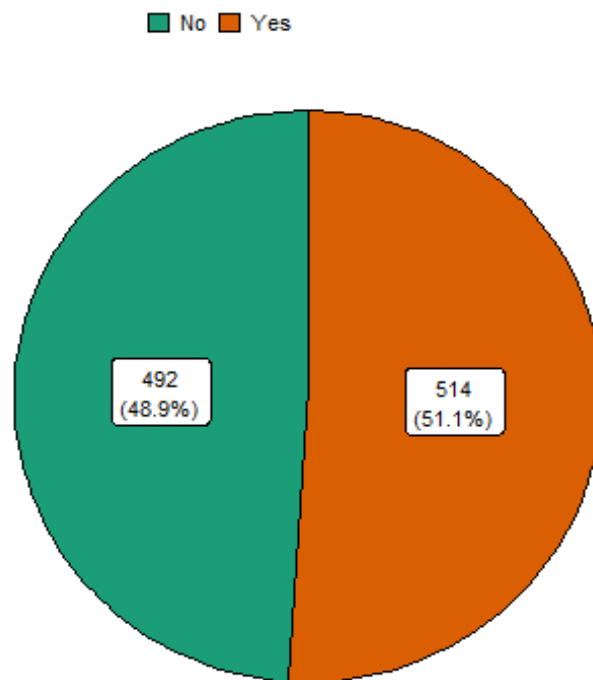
shows the outcome (Yield) of echocardiography. An almost equal number had normal (48.9%) and abnormal findings (51.1%) on echocardiography.
